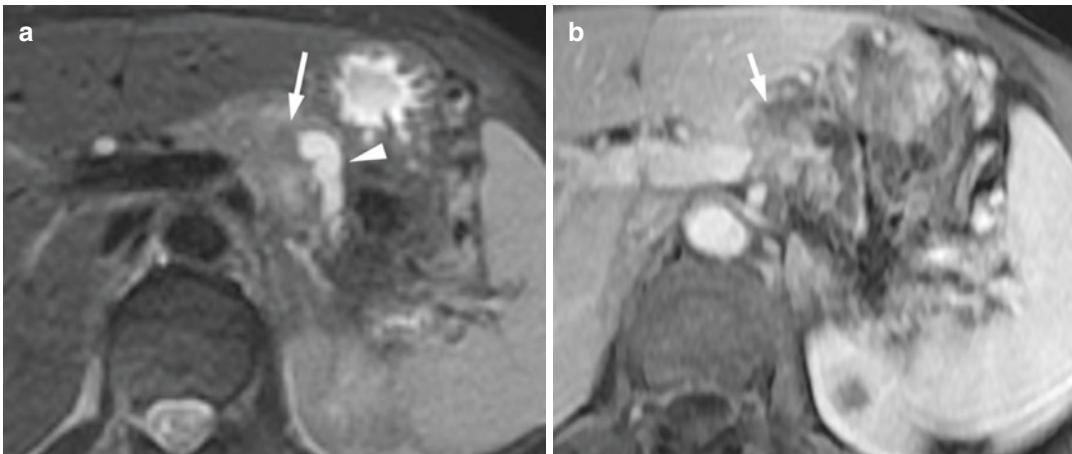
(a) Axial T2 weighted MR image demonstrates dilated pancreatic duct (arrowhead) with abrupt cut off due to pancreatic cancer (arrow) and (b) corresponding
